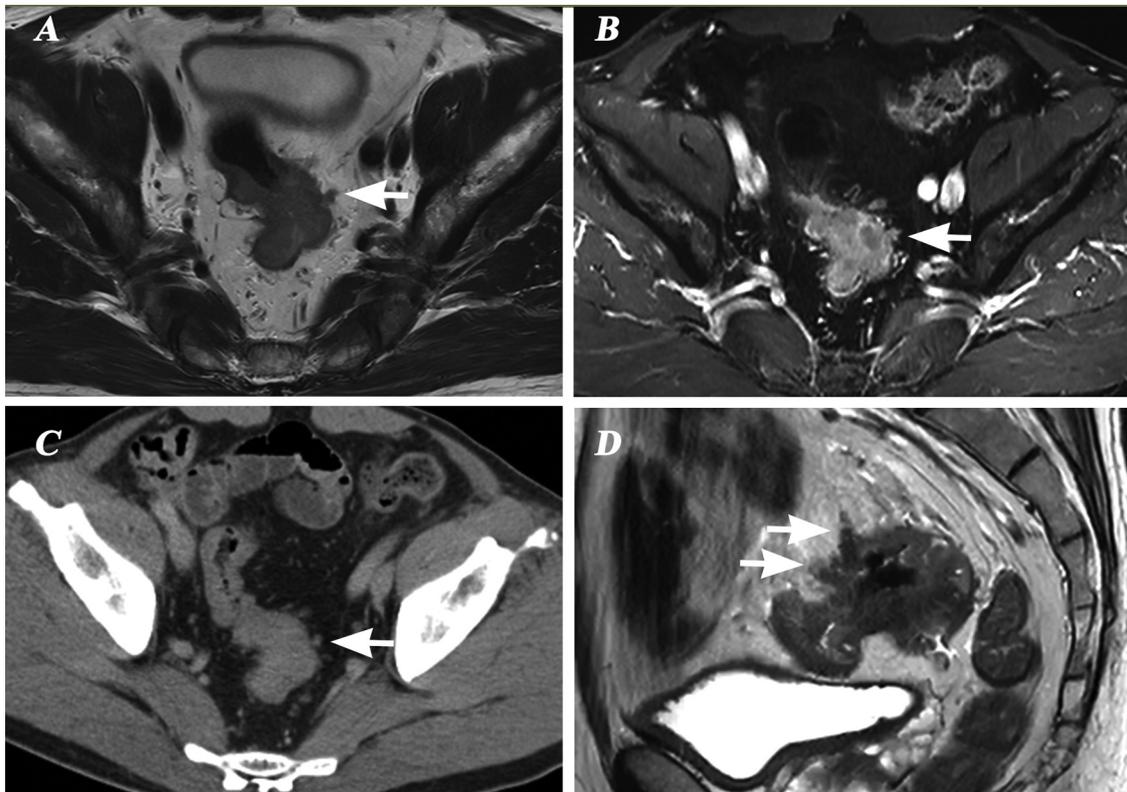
A–C: Colon carcinoma with pathologically proved extramural vascular invasion (EMVI). Axial T2-weighted imaging (A) and post-contrast T1-weighted imaging (B) display a small vascular containing intermediate signal with expanded caliber (EMVI+, subjective score of 3), which was mistaken for a small lymph node in axial post-contrast CT (arrow in C) by readers. D: Another case with pathologically proved EMVI. Sagittal T2-weighted imaging (D) shows the more obvious EMVI than that in A and B, which was also missed by readers with CT (not shown).
